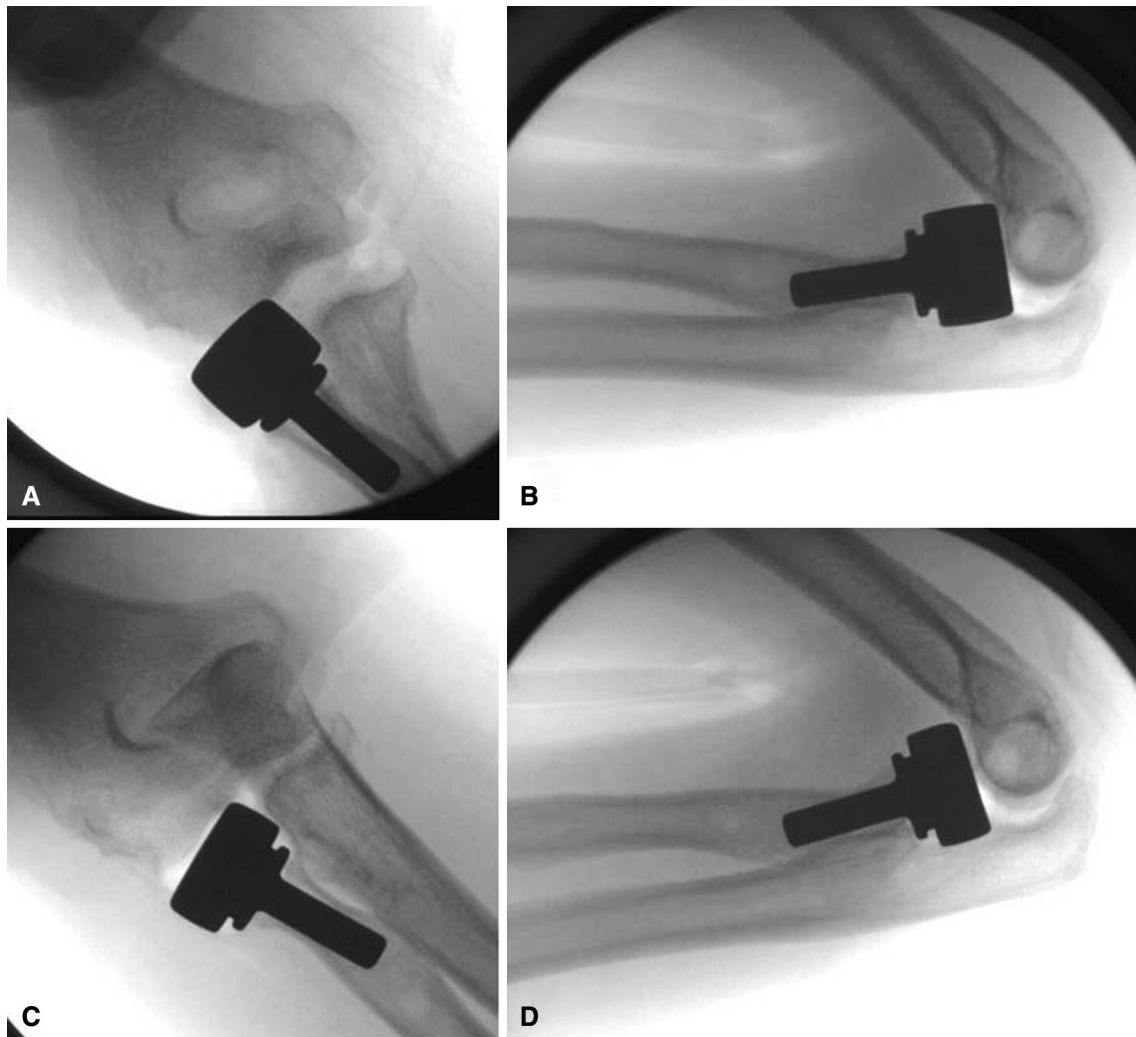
D (A) AP and (B) lateral radiographs show a 22 + 4 mm head clearly overstuffing with gapping of the humeroulnar joint and prosthesis protruding proximal to the lateral edge of the coronoid
